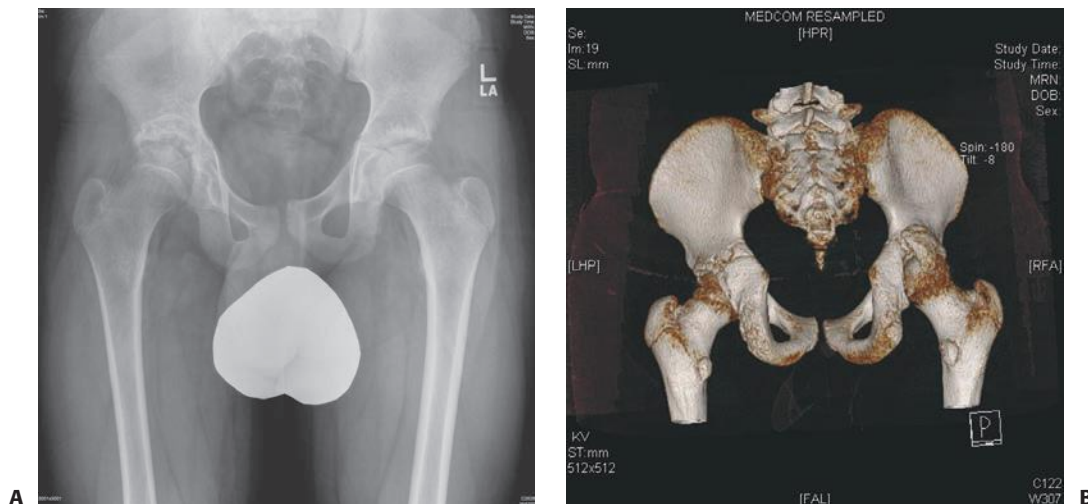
A: Pelvic radiograph of a 12-year old 1 year after an acetabular fracture. The fracture is a malunion with subluxation of the hip joint. B: Three-dimensional CT scan showing the malunited fragment.
